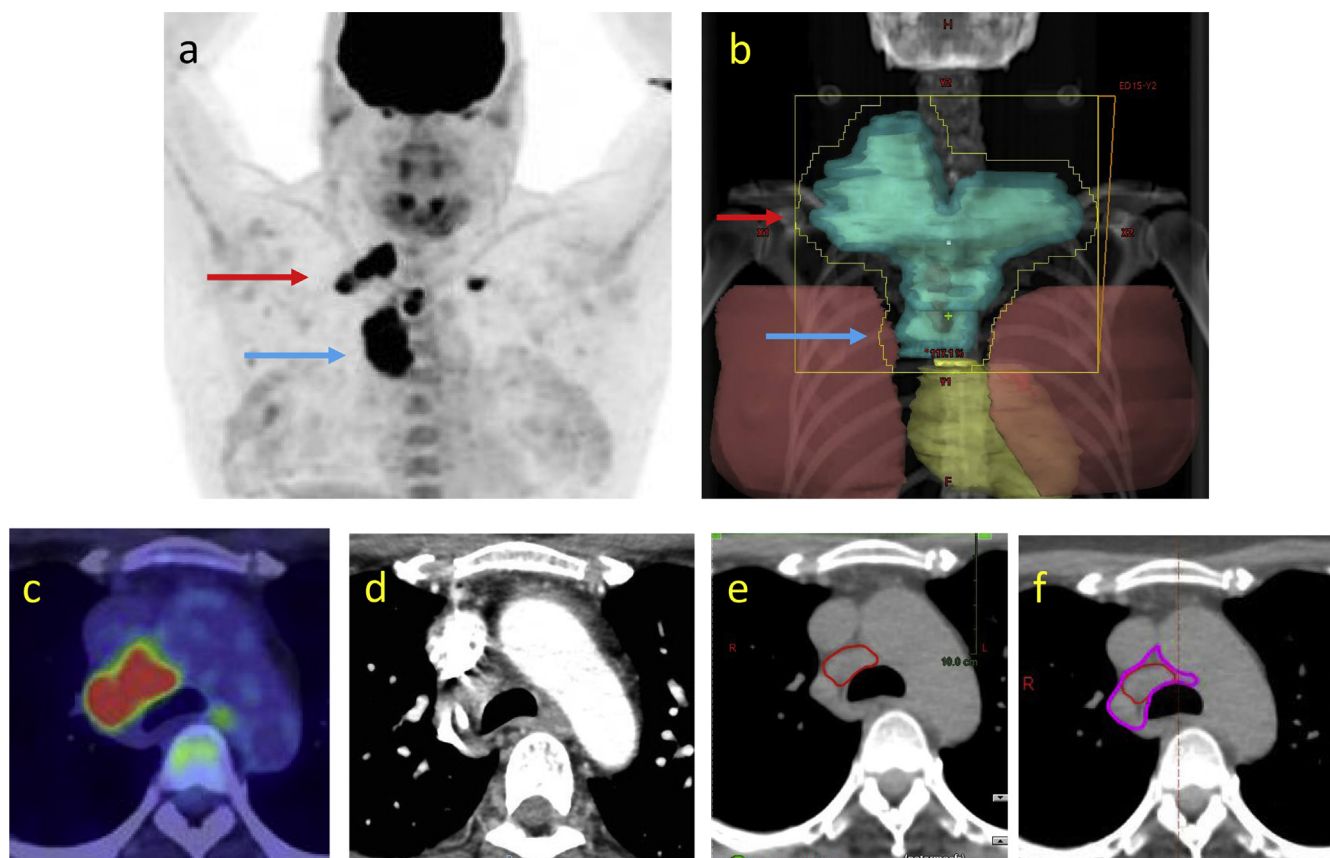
Stage IIA classical Hodgkin lymphoma in positron emission tomography (PET) remission after 3 cycles of ABVD; (a) baseline PET, arms elevated; (b) treatment field on planning image, arms down; (c) baseline mediastinal nodes on PET; postchemotherapy residual mass on (d) contrast computed tomography; (e) planning CT; and (f) clinical target volume (CTV). Well-defined mediastinal anatomic boundaries allow precise CTV delineation (true involved-node radiation therapy), with generous supraclavicular CTV expansion allowing for anatomic changes due to altered arm position (involved site radiation therapy volume).
